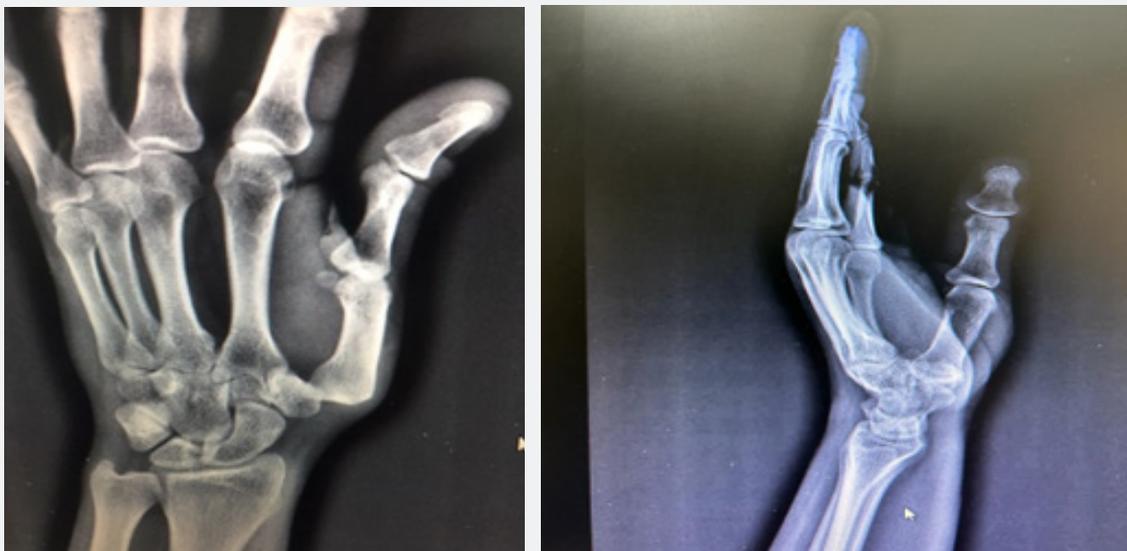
A_P and L_L radiograph of the hand showing the dorsal dislocation of the TM joint and with stable condition.
